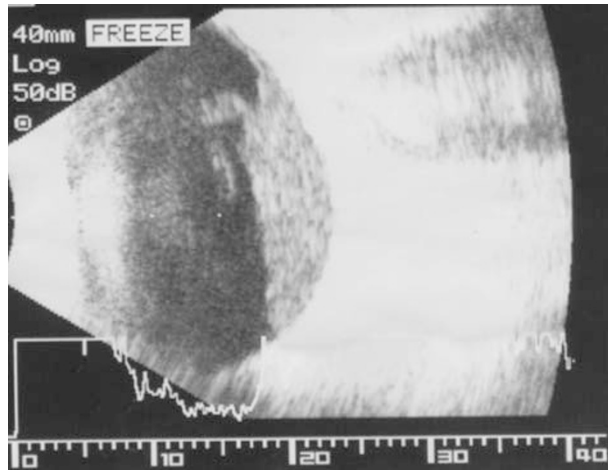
Left eye B scan ultrasound showing preretinal haemorrhage.
